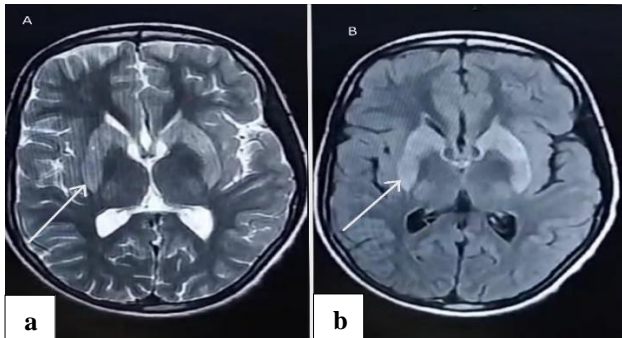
Contrast-enhanced MRI of brain showing hyperintensity (arrows) in the bilateral caudate nucleus, globus pallidus, and lateral thalamus, (a) T2 weighted MRI, and (b) fluid-attenuated inversion recovery (FLAIR).
